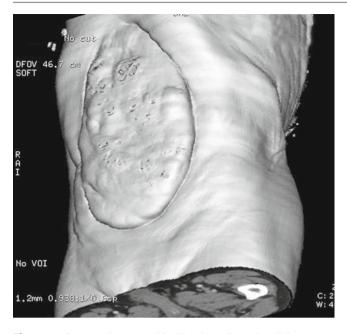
Computed tomographic (CT) three-dimensional (3D) reconstruction as a tool for preoperative surgical technique programming
